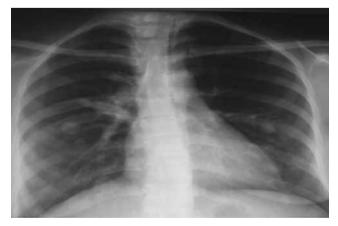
Chest X-Ray : improvement and radiological cleaning of alveolar and nodular lesions under general corticosteroid therapy
